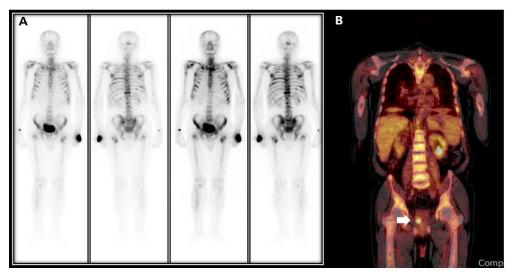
(A) Disseminated bone metastasis is observed. (B) A focal hypermetabolic lesion is noted in the prostate (max SUV 6.2) (arrow), and diffuse hypermetabolism is observed in the whole bone marrow.
